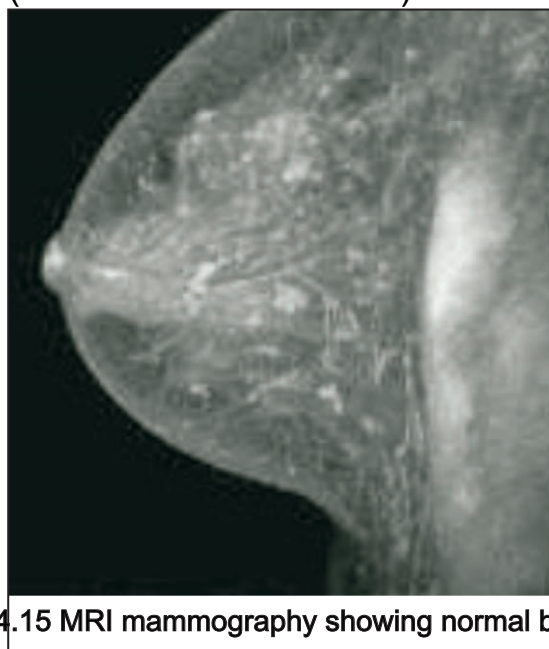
MRI mammography showing normal breast
